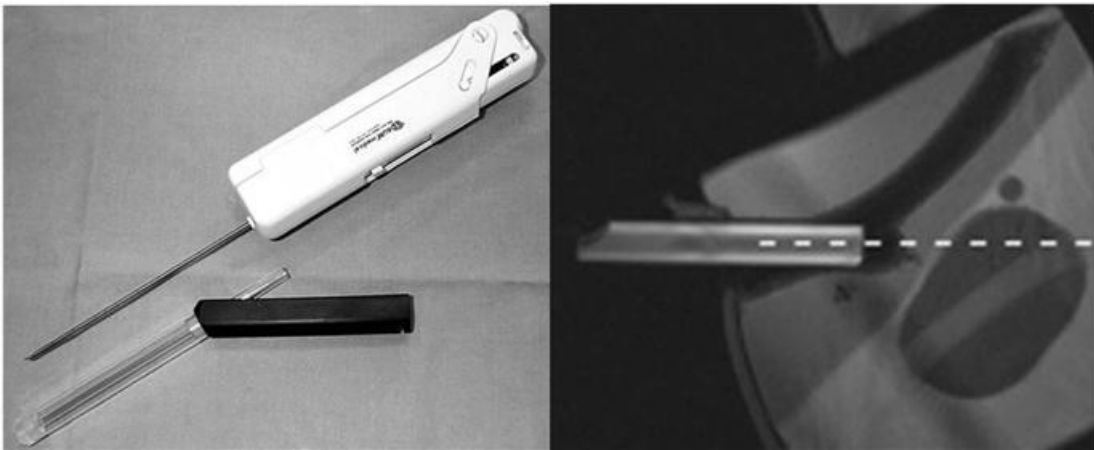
(l) MR contrast gel-filled needle guide with biopsy needle gun and (r) planar MR image of needle guide [Beyersdorff, 2004; Oliveira, 2007].
